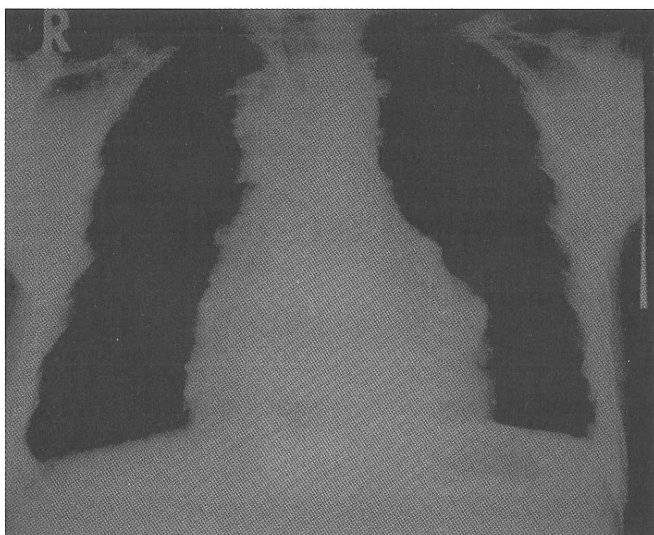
Chest x-ray film on admission: cardiomegaly, left pleural effusion and widened mediastinum.
